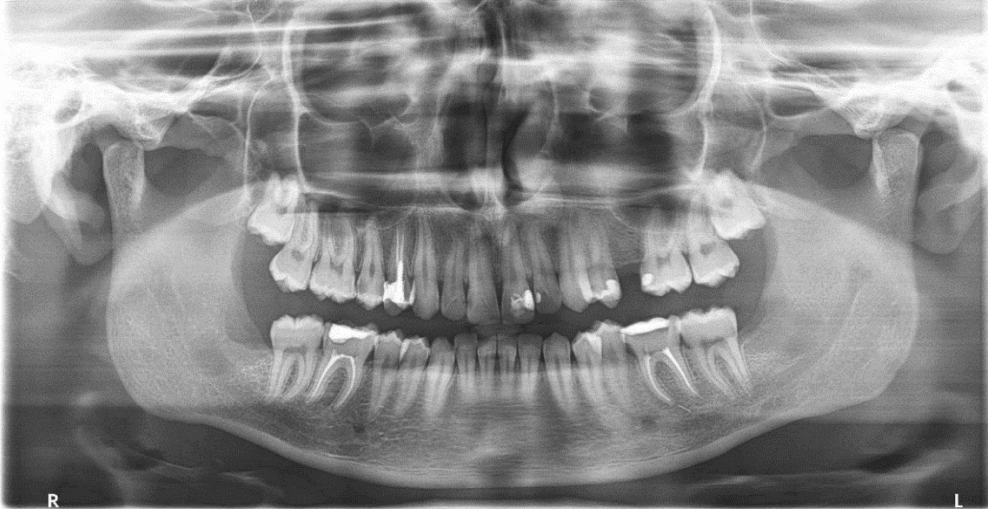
Postoperative panoramic radiography
